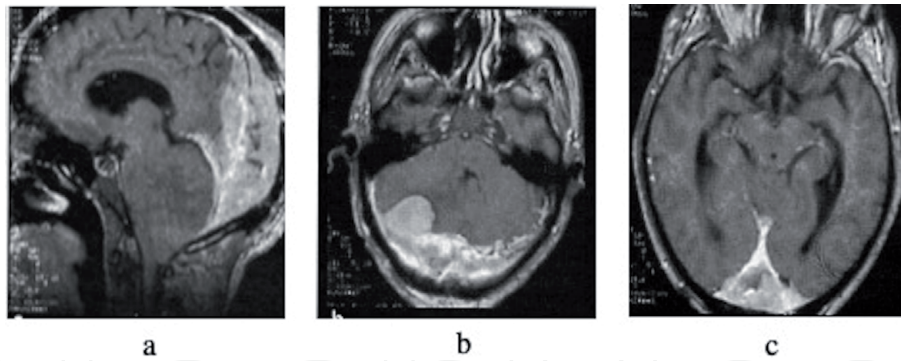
Post-contrast MRI of a 70 years old woman with history of previous (7 year before) surgical resection (Simpson 3) of a WHO grade II meningioma of the posterior parasagittal region: sagittal (a) and coronal (b-c) sequences: diffuse recurrence with extensive dural and superior sagittal sinus involvement and tumor nodules at the posterior fossa. No reoperation was decided.
